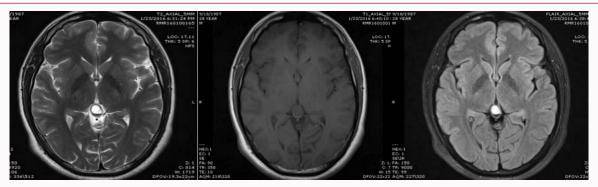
Well-defined oval shaped cystic pineal lesion (15 mm × 12 mm × 10 mm, AP × ML × CC) is seen which is T1 isointense/T2 hyperintense and is not suppressed on FLAIR.
